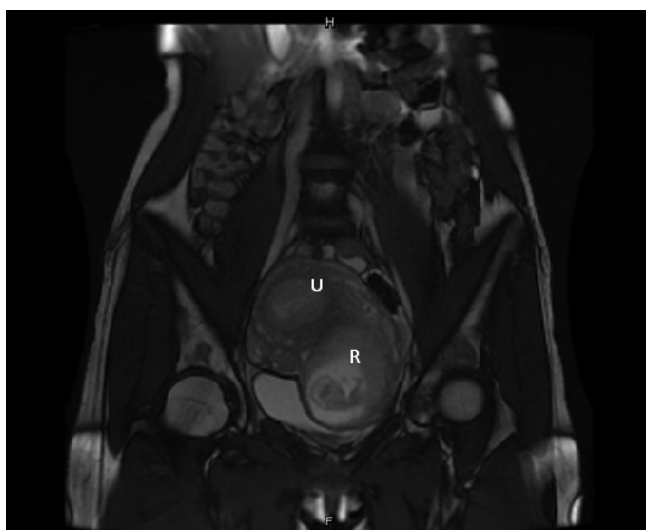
Magnetic resonance imaging T2 coronal view of the uterus (U) and the rudimentary horn (R) pregnancy.
